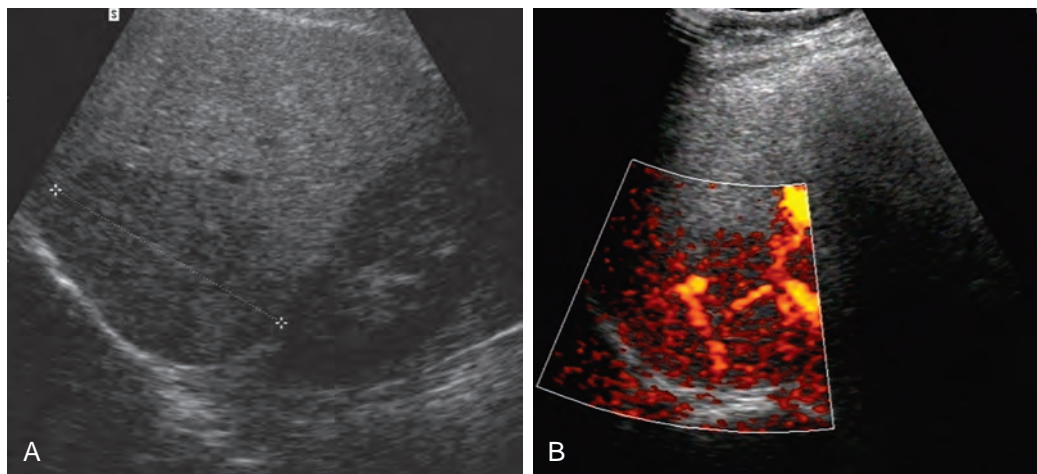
Focal nodular hyperplasia: color Doppler ultrasound. A. There is a large hypoechoic mass in the right lobe of the liver. B. It is quite vascular on color Doppler imaging.
